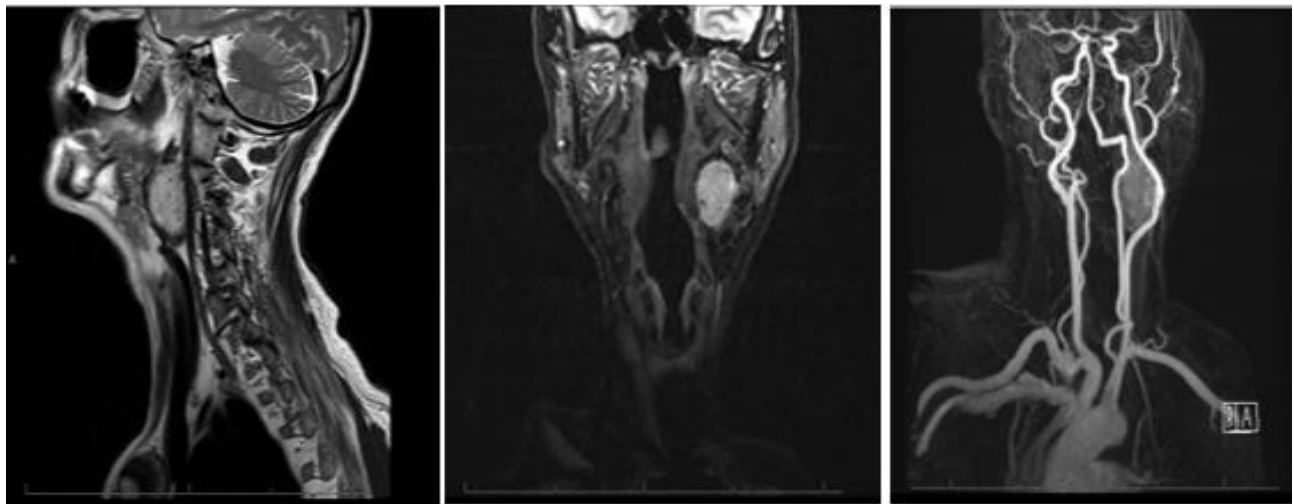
Magnetic resonance imaging angiography showed a well-defined mass in the left carotid space causing splaying of the internal carotid and external carotid arteries, compatible with the diagnosis of a carotid body tumor (paraganglioma).
